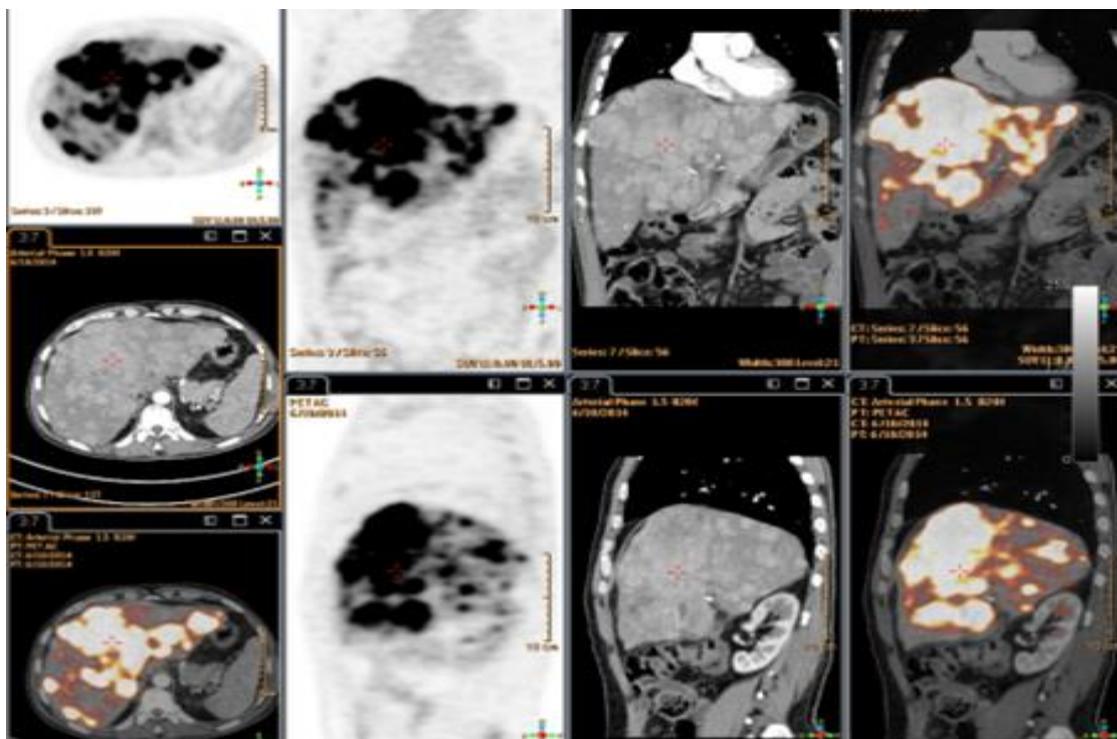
62 ys old male with liver cirrhosis with multiple hepatic focal lesions of large size and heterogenous enhancement in triphasic CT, Biopsy revealed multi-centric poorly differentiated adenocarcinoma
